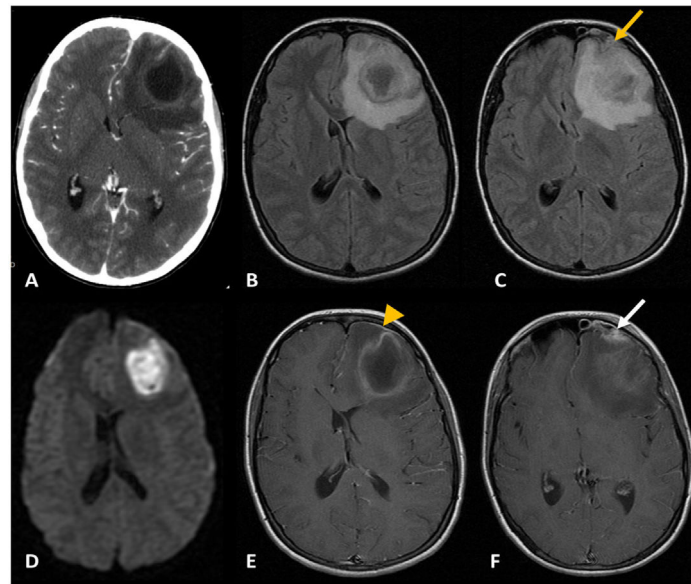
Cerebral abscess: Axial ceCT, soft-tissue window (A), shows a rim-enhancing frontal lobe collection with perilesional edema, causing mass effect with midline shift, suggestive of cerebral abscess. T2WI FLAIR (B and C) in two different planes, DWI (D) and post-contrast T1WI (E and F) in two different planes confirm the presence of a frontal lobe abscess with extensive perilesional edema, associated to crescent-shaped high T2/FLAIR-signal (yellow arrow), suggestive of subdural empyema, and leptomeningeal enhancement (arrowhead) suggestive of focal meningitis. At a lower level (C and F), it is demonstrated the presence of mucosal thickening of the left frontal sinus in continuity with the intracranial complications (white arrow in F).
